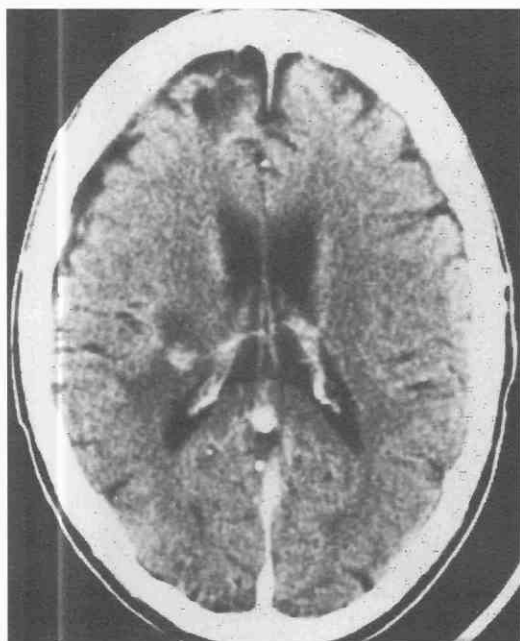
Radiation necrosis, contrast-enhanced CT scan. A small, enhancing focus within the right posterior corona radiata is surrounded by white matter lucency. (The right frontal pole encephalomalacia resulted from a previous biopsy establishing the diagnosis of intracranial lymphoma.) The differential diagnosis of the contrast-enhancing lesion includes infection or recurrent tumor. At autopsy, radiation necrosis was found without lymphoma or abscess.
